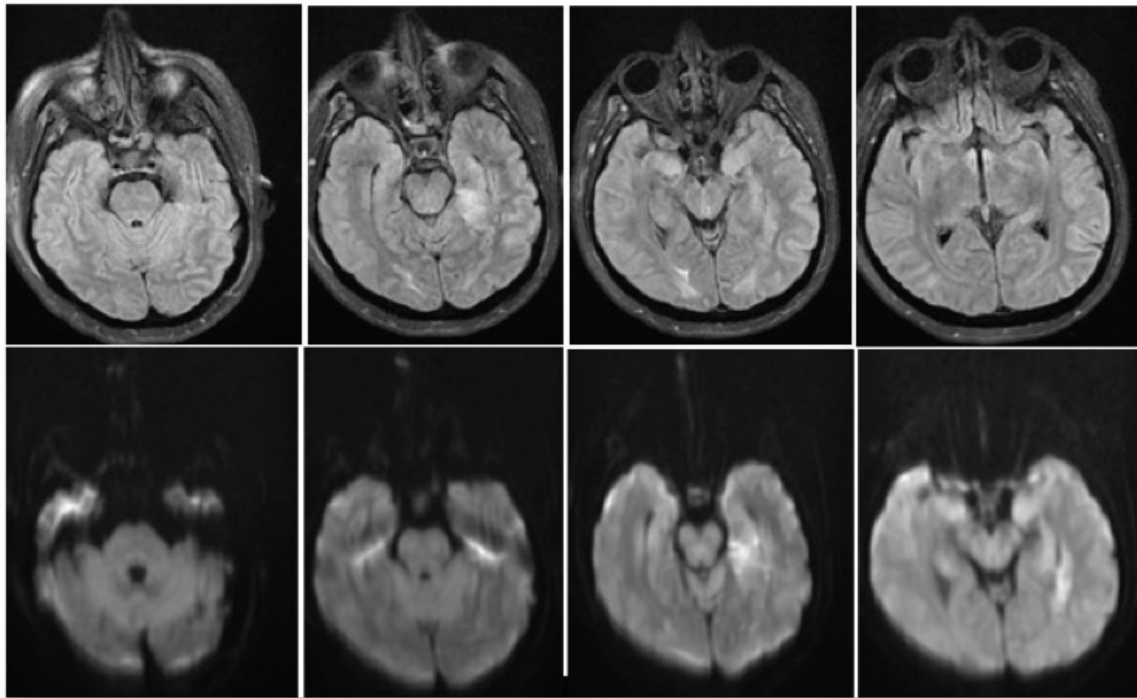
Patient's first Brain MRI Findings.
